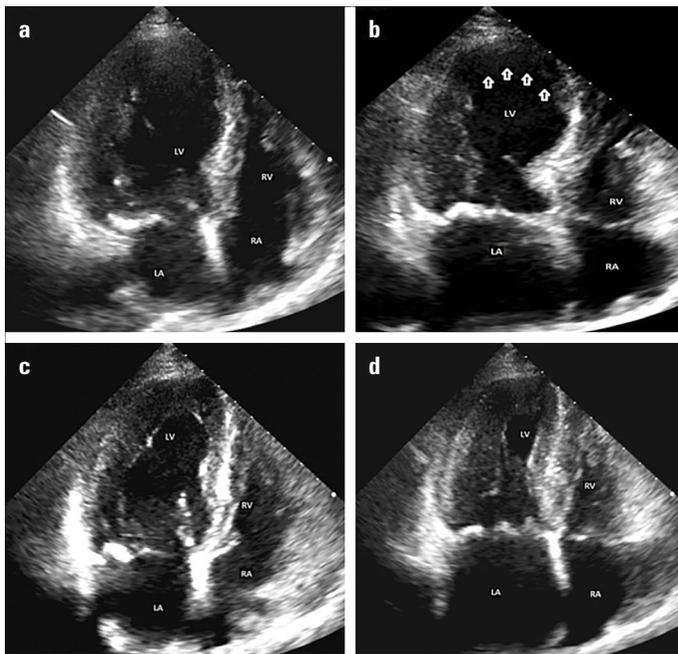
Transthoracic echocardiogram (apical 4 chamber view) on admission showing apical ballooning of the left ventricle in diastole (a) and systole (b). One week after discharge, a repeated echocardiogram showed disappearance of the apical ballooning in diastole (c) and systole (d). LV, left ventricle; RV, right ventricle; LA, left atrium; RA, right atrium
